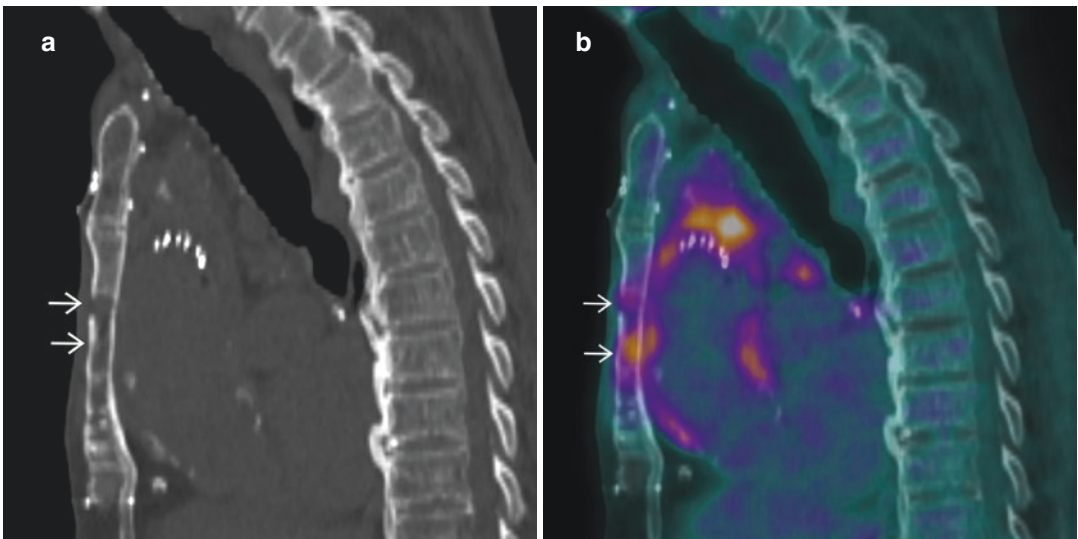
¹⁸F-FDG PET/CT of tuberculous osteomyelitis. 83-year-old man with thoracic aortic dissection who had prolonged fever after thoracic aortic stent-graft placement. Sagittal (a) CT and (b) PET/CT fusion images show an
